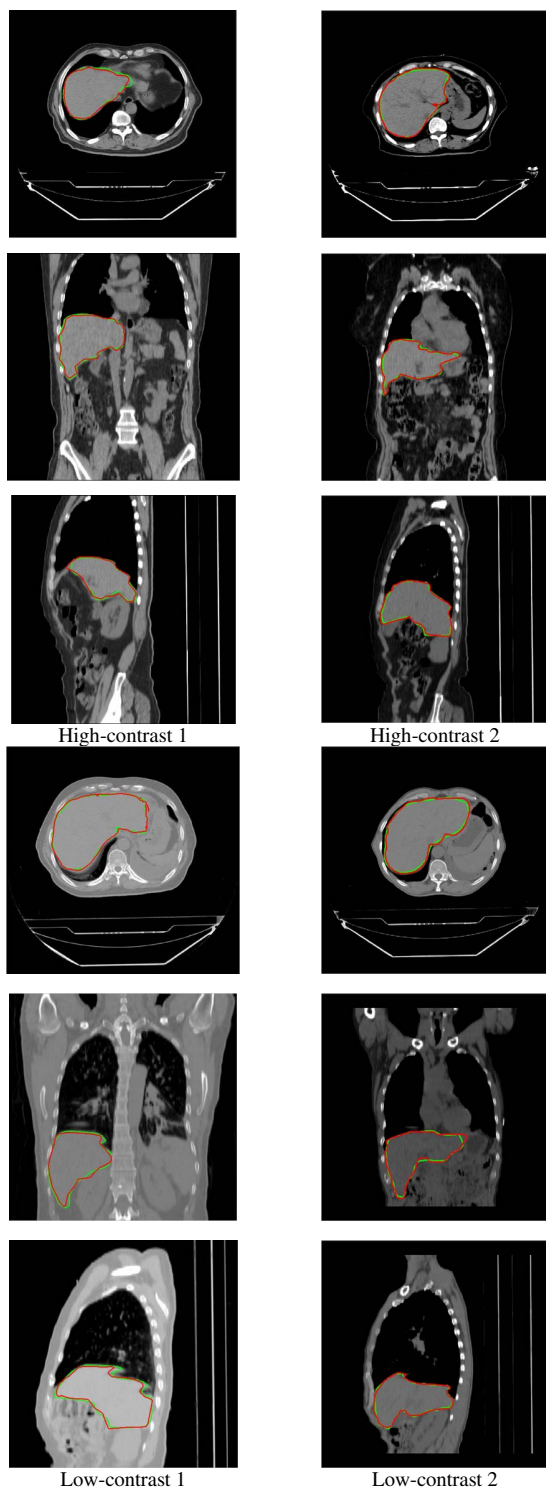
The transverse, coronal and sagittal views of liver volume segmentation by our method delineated in red and manual segmentation delineated in green for high/low-contrast CT volumes respectively.
